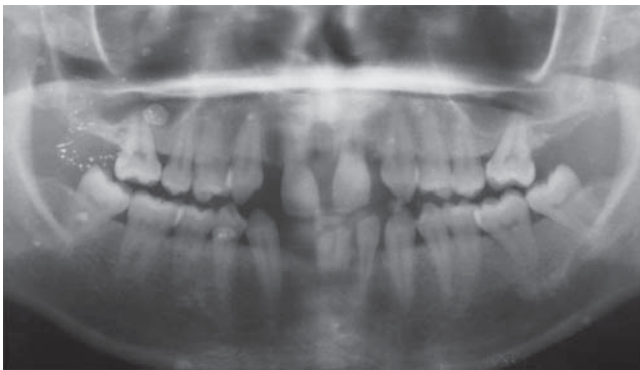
Orthopantomogram of the case
